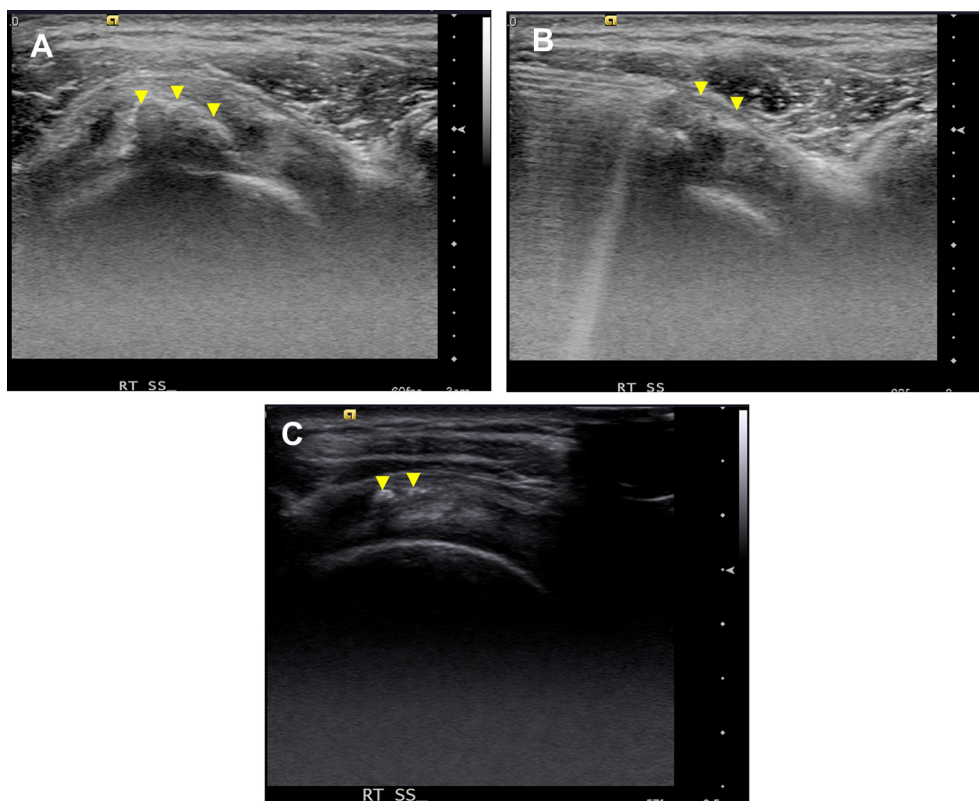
A 45-year-old female patient complained of right shoulder pain for >1 year. Ultrasonography showed an arc-shaped calcification in the right supraspinatus tendon (arrowheads in A). After ultrasonography (US)-guided repeated puncture, 2 mL of xylocaine was injected into the right subdeltoid bursa (arrowheads in B). Six months later, ultrasonography showed only tiny calcification spots (arrowheads in C), and the patient reported marked reduction of pain.
